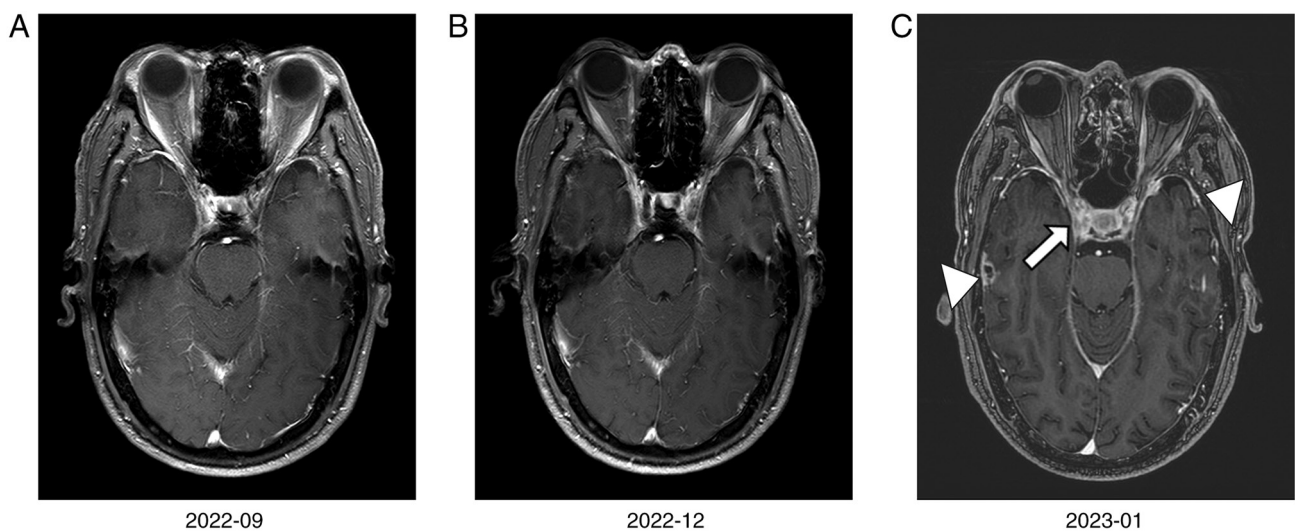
Serial contrast-enhanced T1-weighted brain magnetic resonance imaging demonstrating the evolution of radiologically suspected meningeal disease. (A) September 2022: No abnormal meningeal thickening or enhancement is observed in the cavernous sinus region. (B) December 2022: The cavernous sinus region remains without definite meningeal thickening. (C) January 2023: Multifocal nodular and patchy meningeal enhancement is observed in the bilateral temporal and parieto-occipital regions, with right-sided predominance (white arrowheads). Irregular thickening and marked enhancement of the meninges adjacent to the cavernous sinus are indicated by the white arrow.
